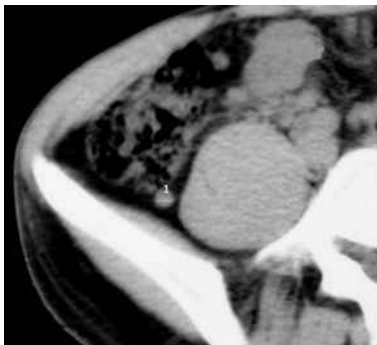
Axial CT image shows a normal appendix measuring 5mm, located posterior to the caecum.
